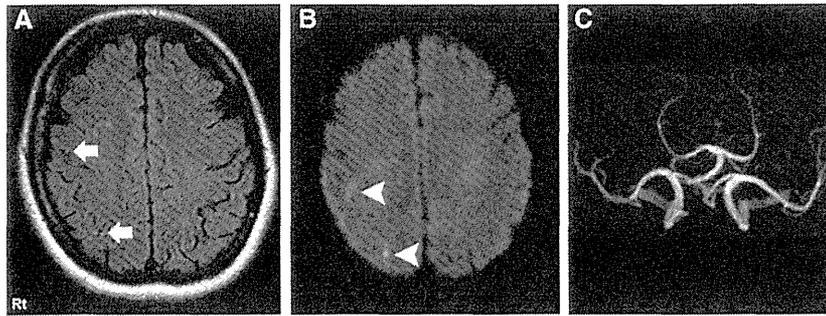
Brain MRI of a 53-year-old woman with transient ischemic attack (TIA) caused by paradoxical embolism. A, Initial fluid-attenuated inversion recovery (FLAIR) images 80 min after a 1-min attack of left hemiparesis showing 2 dot-like high intensities in the right middle cerebral artery territory (arrows). Initial diffusion-weighted imaging (DWI) showing no abnormal findings. B, Follow-up DWI showing hyperintense lesions close to the area where the fluid-attenuated inversion recovery vascular hyperintensity (FVH) are initially identified (arrowhead). Follow-up FLAIR images 6 d after the attack showing disappearance of the FVHs. C, MRA showing no arterial occlusive lesions at the initial assessment. The patient was diagnosed as having a patent foramen ovale and protein S deficiency during hospitalization. She did not experience a TIA or stroke after the initial TIA episode.
